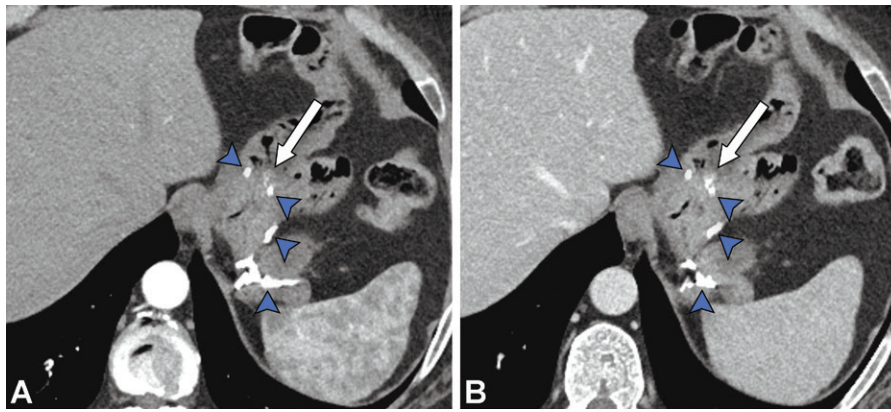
Roux-en-Y gastric bypass with active bleeding in a 49-year-old woman with a history of melena. Axial arterial phase (A) and portal venous phase (B) CTA images show contrast extravasation in the arterial phase at the gastrojejunostomy site (arrow in A), which changes in size, attenuation, and shape in the portal venous phase (arrow in B). There are multiple adjacent surgical clips related to Roux-en-Y gastric bypass surgery (arrowheads). The active bleeding was caused by a marginal ulcer adjacent to the gastrojejunostomy site, which was noted at upper endoscopy.
